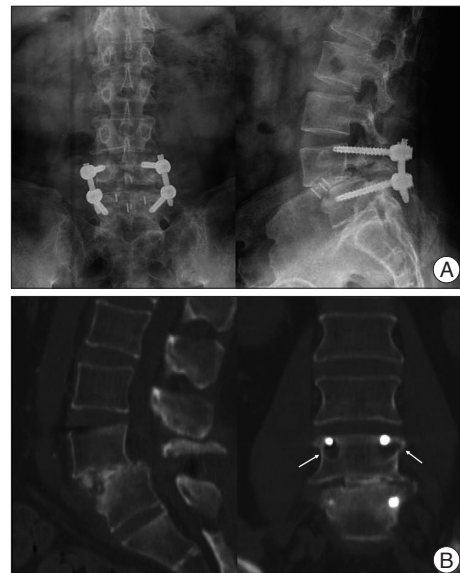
Plain radiographs (A) and CT sagittal and coronal reconstruction images (B) at postoperative 7 weeks. A : Anterior dislodgement of the fusion cage as well as reduction loss of the spondylolisthesis at the L4-5 level. B : CT images showing that the intervertebral space was not fused and the L4 pedicle screws were loose with osteolysis (white arrows).
